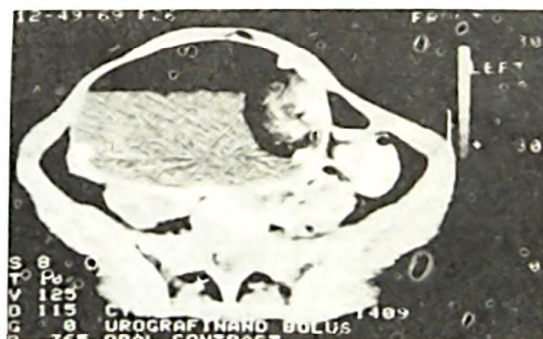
(Case 5): CT scan showing an upper supematant fat layering above a cystic lower component and with a high attenuation nodule with teeth to the left. The nodule is circumscribed by fat. The entire mass is walled round by shell of high attenuation structures i.e. bone.
